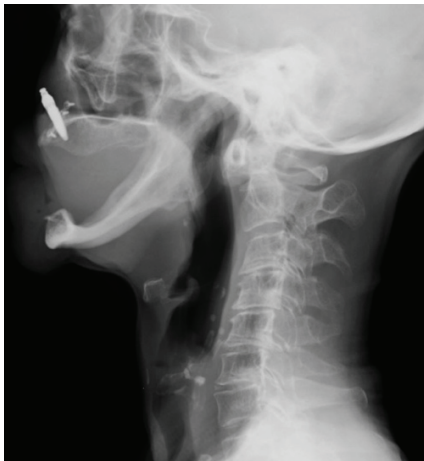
Lateral C-spine radiograph
